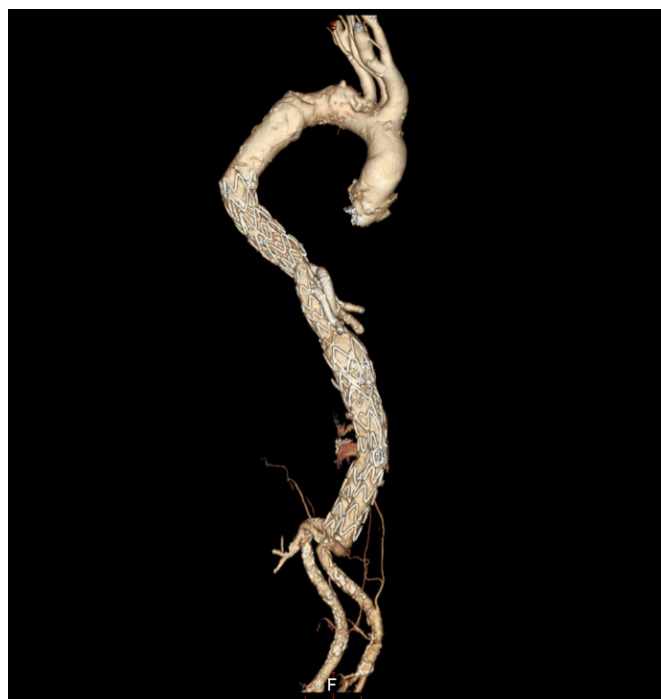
Postoperative CT-angiography. 3D-Volume rendering, with visceral vessels well-perfused
